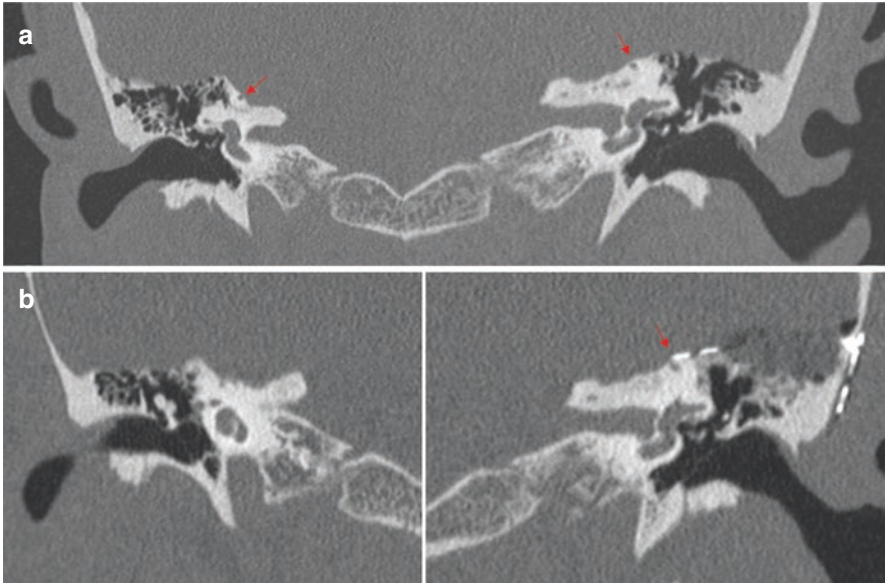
High resolution computed tomography (HRCT) of a 43-year-old male with bilateral SCDS who elected for repair of the left-sided dehiscence. (a) Preoperative HRCT of the temporal shows both left and right sided dehiscence (arrows), with symptom presentation of amplification of internal sounds, aural fullness, rapid hearing loss, and tinnitus. (b) Postoperative HRCT of the left-sided dehiscence (arrow) with the sealing technique. At the 15-month follow-up, the patient had alleviation of aural fullness and amplification of internal sounds
